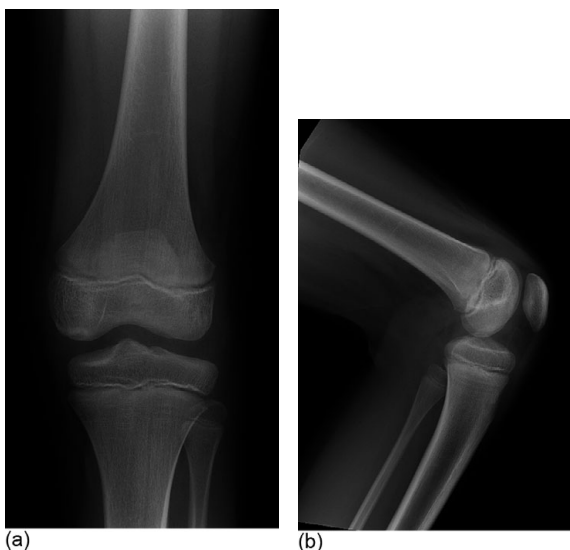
(a) Anteroposterior (AP) and (b) lateral radiographs knee
